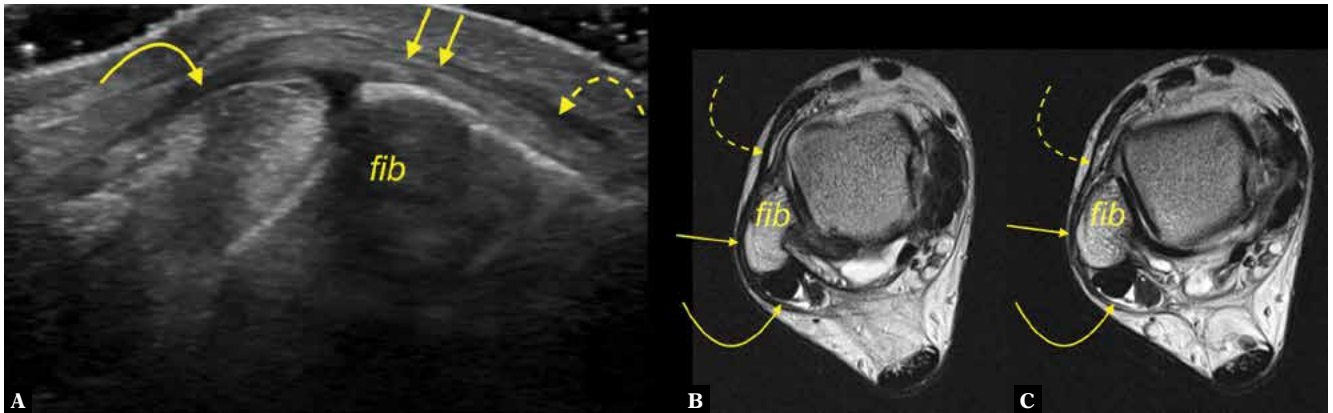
A 24-year-old patient with pain anterior to the lateral malleolus. A. transverse section on ultrasound, B, C. T2-weighted slightly oblique sections. The interconnection (arrows) between the SPR (curved arrow) and IER (dashed arrow); fib – fibula
